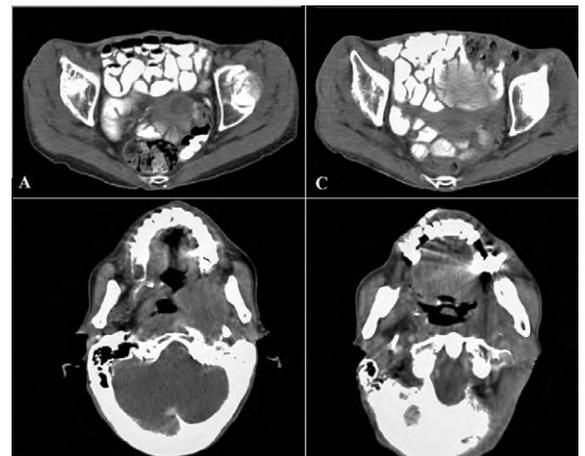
a) CT scan showing the presence of a tumor mass, replacing the cervix b) CT scan demonstrating a soft tissue mass with extension to the parapharyngeal space c) CT scan demonstrating apparent reduction in size of the tumor mass the cervix and d) oral cavity after 18-month follow-up
